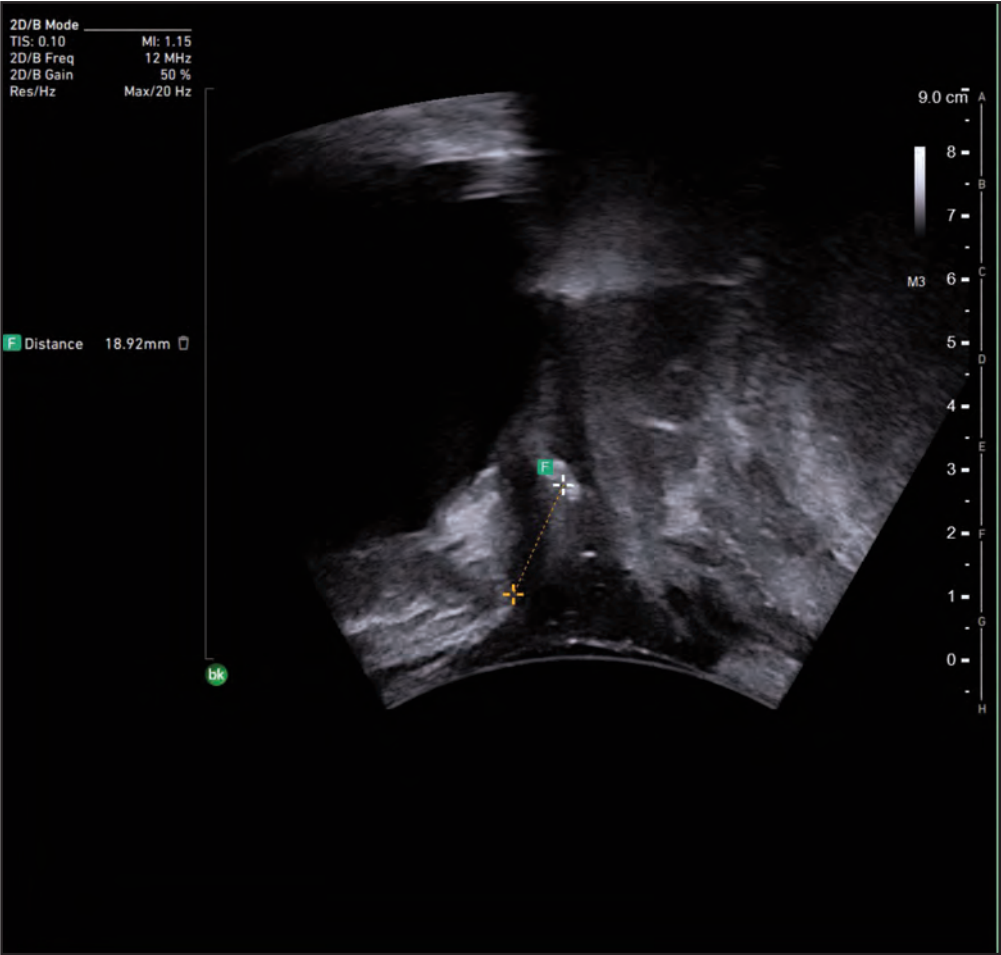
Transperineal ultrasound showing sling-pubis gap
